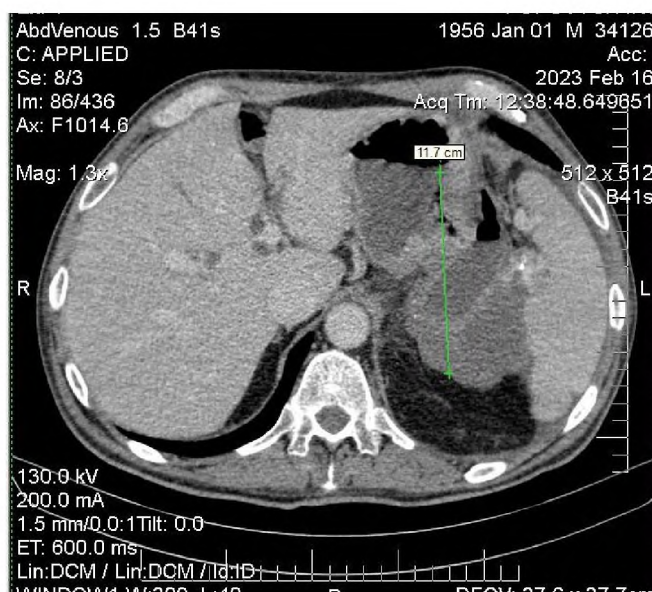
CT data 16.02.23, tumor 115x86x72 mm
